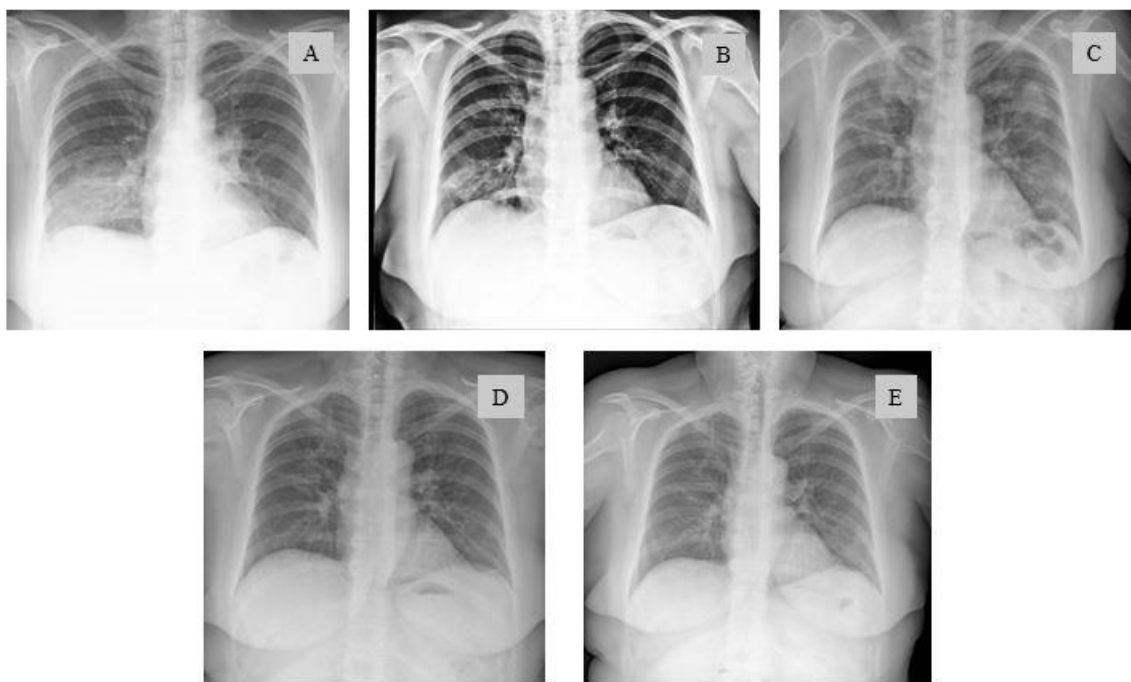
Chest radiographs from Case No. 1 patient chronologically, from the first manifestation of the disease during the first hospitalization at regional medical center (RMC) (A), after initial empiric antibiotics treatment at RMC (B), when admitted to our clinic due to developing deterioration of general condition (C), 10 days after initial corticosteroid treatment (D), and on the second follow-up after hospital discharge (E)
